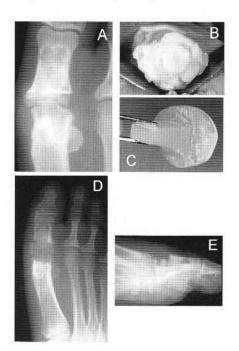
Patient described in Case 1 with chronic joint pain and stiffness. A) Radiograph 5 years postoperative hemi silicone implant reveals metatarsal head erosions and cystic changes. B) Intraoperative appearance of metatarsal head articular surface showing osteophytosis and degenerative changes. C) Removed hemi implant reveals deformation and fatigue fracture. D) and E) Reconstruction involved revision with a double-stem hinge implant. heroic. Revision to another joint implant should probably be reserved for the patient without significant host reaction to any of the prior implanted biomaterials. A situation encountered in the past was that of the failed silicone hemi. The length of the proximal phalanx, integrity of the flexor apparatus, and quality of bone stock often determine the most appropriate reconstruction. Revision with a double stem hinged silicone implant may provide a satisfactory reconstruction. Revision to a component total joint replacement has also been attempted but this may be more difficult and past success really does not indicate this as a viable option. Hemi metallic implants are also in clinical use and potential revision is aided with the relatively limited bone resection required at the initial surgery.
